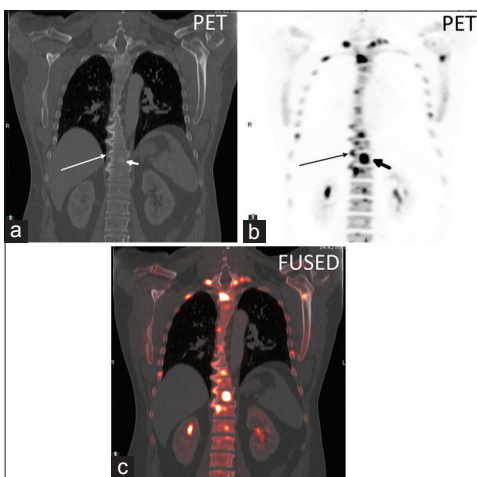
(a) Coronal CT, (b) coronal ^{18}F NaF PET, and (c) axial fused PET/CT image in a thoracic spine degenerative disc osteophyte (long arrow) with a SUV_{max} of 27.3 and an adjacent sclerotic vertebral body metastasis (short arrow) with a SUV_{max} of 64.0
